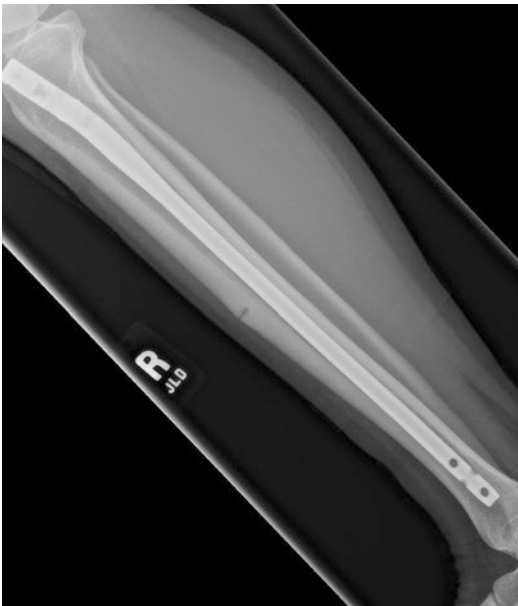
Lateral X-ray of the tibia and fibula following intramedullary nail placement in a patient with a “dreaded black line.”
